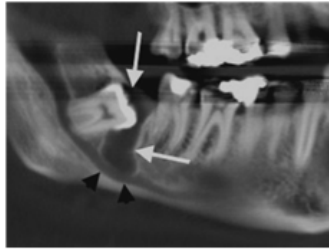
Dentigerous cyst (white arrows) related to an unerupted right mandibular third molar, shown on a panoramic MIP reconstruction from a CT of the mandible. Note the mild inferior displacement of the inferior alveolar canal (black arrowheads) by the cyst.
